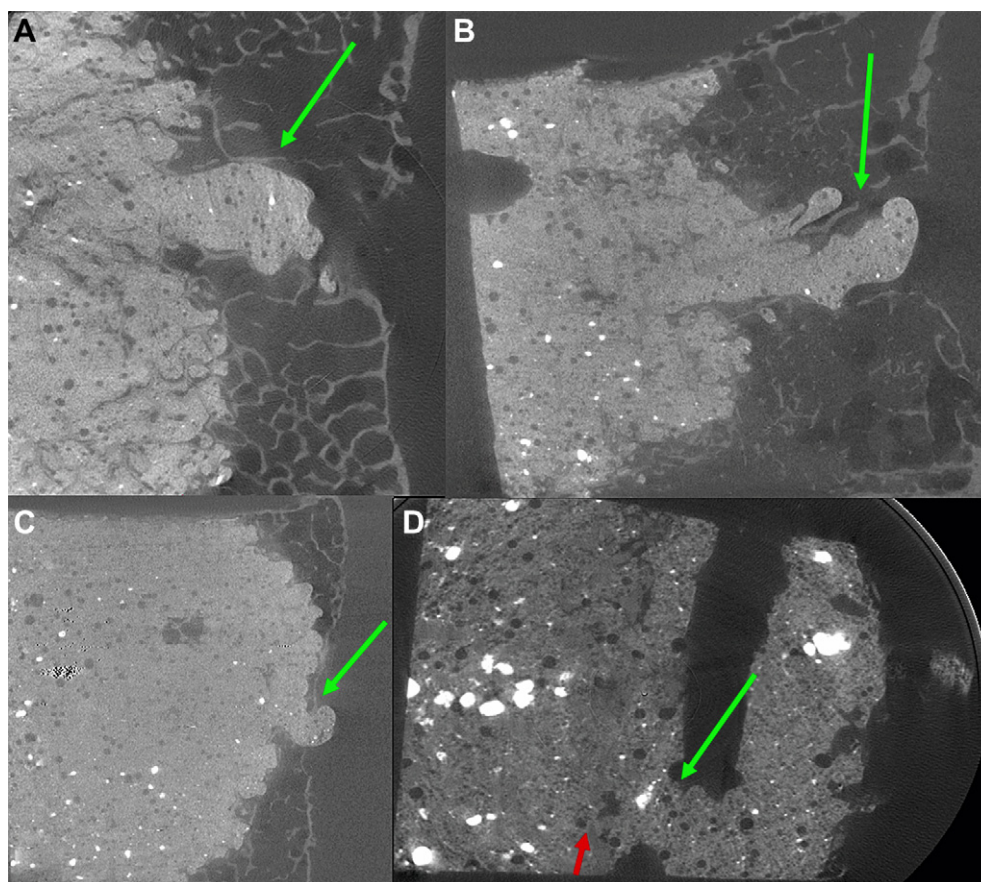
Micro-computed tomography (CT) images of the basivertebral foramen showing different stages of cement extravasation. (A) Cement within the foramen without extravasating. (B) Cement reaching the edge without protruding. (C) Small amount of cement protruding. (D) Cement leakage through the foramen. Red arrow shows the estimated point of extravasated cement.
